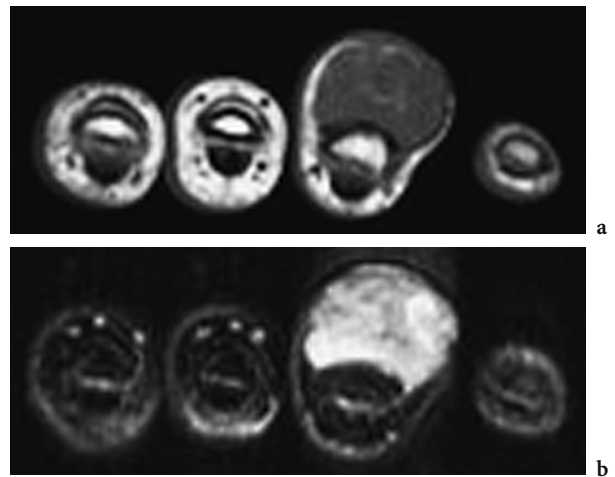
Proliferating hemangioma of the finger demonstrating: a low signal on T1-weighted image and b intense parenchymal enhancement with gadolinium
